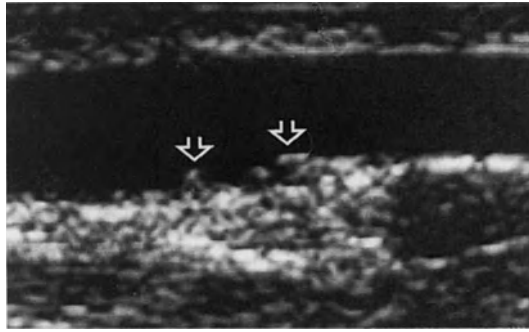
Irregularities of the vessel wall (arrows) in the venous limb of a dialysis fistula. These “intimal flaps” may be better demonstrated by conventional B-mode ultrasound since they are sometimes obscured by overlaid color when CCDS is used
